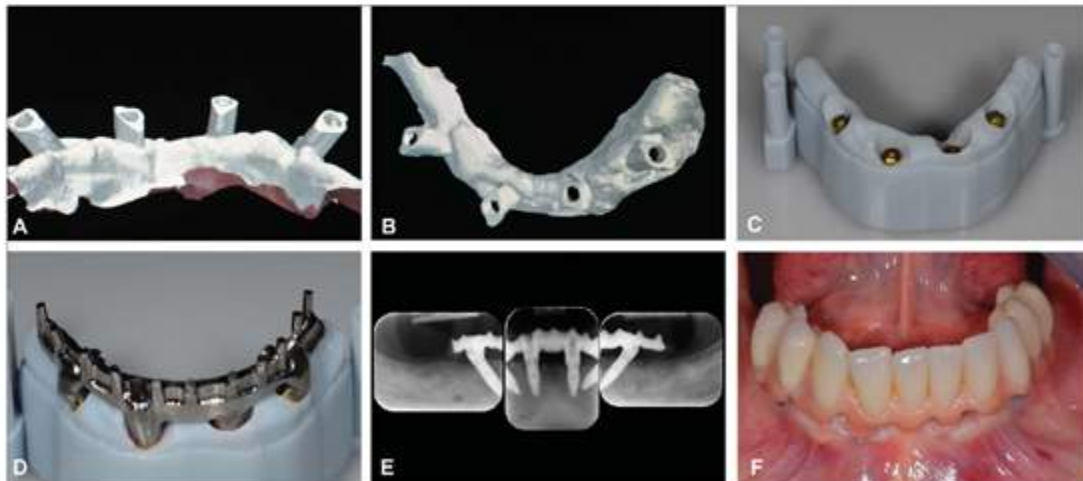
Scan bodies fit into the dental implant fixture. Image of virtual framework (A and B); occlusal view of the stereolithographic model (C); framework screwed on the stereolithographic model (D); radiographic evaluation of the marginal fit of frameworks screwed onto the implants (E); and final restoration (F).
